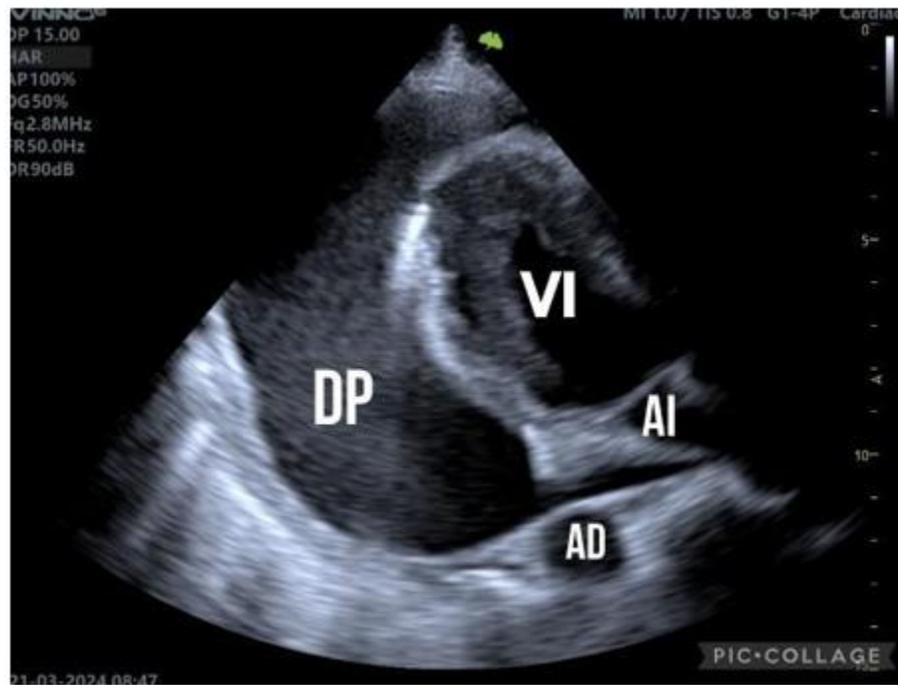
Transthoracic echocardiogram, parasternal long-axis view, shows evidence of massive pericardial effusion. DP: Pericardial Effusion, LV: Left Ventricle, LA: Left Atrium, and RA: Descending Aorta.
